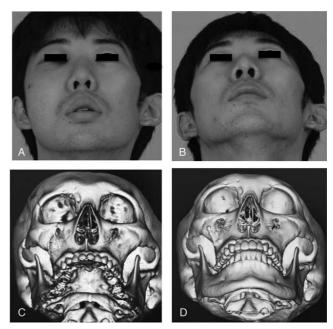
Representative case. The preoperative photograph shows a depressed right malar deformity (A) and the preoperative 3-dimensional computed tomogram (3D CT) reveals a comminuted fracture of the zygomaticomaxillary buttress and inferior orbital rim without the zygomatic frontal suture shearing (C). The postoperative photograph (B) and the postoperative 3D CT (D) show good contour and favorable malar alignment after 1-point fixation at the zygomaticomaxillary buttress.
